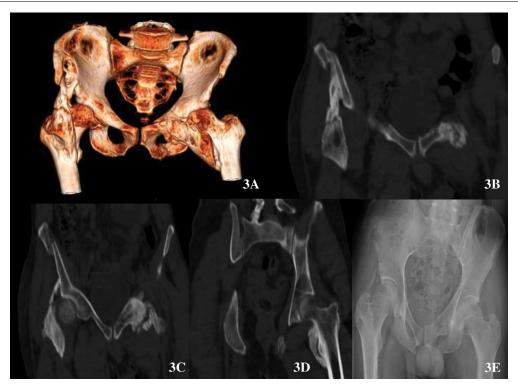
2nd patient: A) Preoperative pelvis 3D-scan image. B) Right hip osteoma: Proximal iliac implantation. C) Right hip osteoma: Distal iliac implantation and left hip osteoma: Proximal implantation on the ilio-pubic branch. D) Left hip osteoma: Femoral implantation. E) Postoperative pelvis X-ray.
